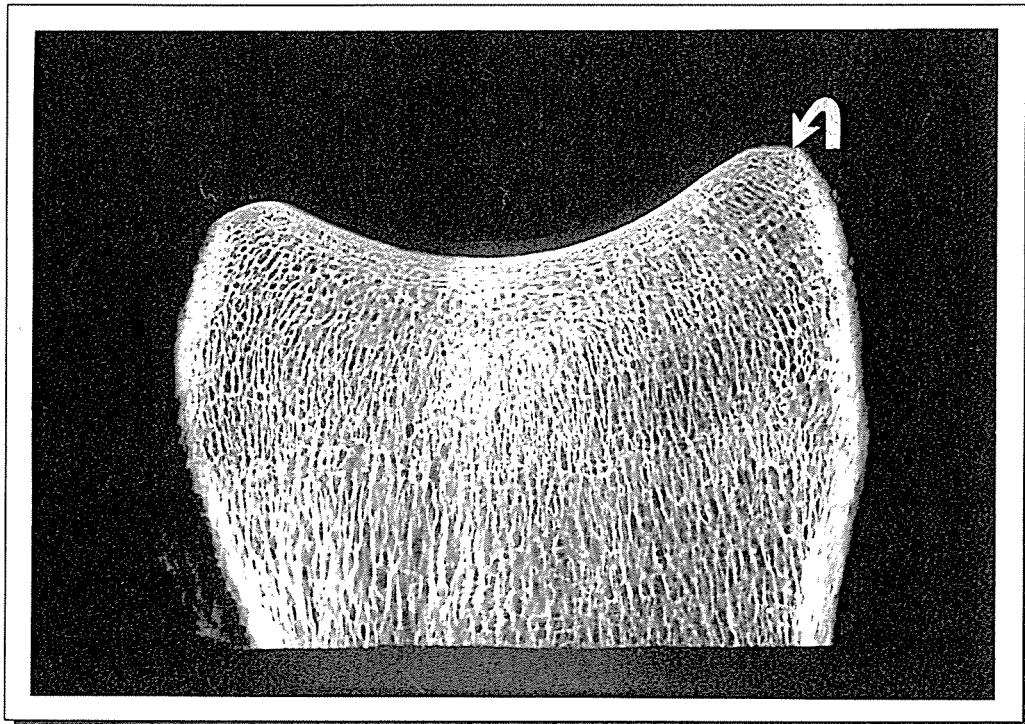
Cabinet radiograph of a 2mm thick sagittal bone slab from proximal P1. The proximo-dorsal eminence appears smooth and intact (arrow).
